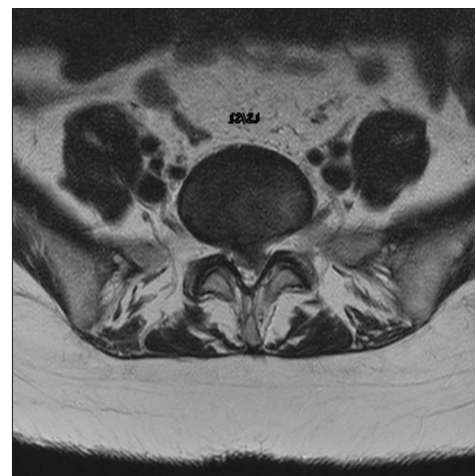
Axial magnetic resonance imaging image showing herniated disc fragment occupying >50% of the spinal canal in the axial plane at the L5S1 level.
